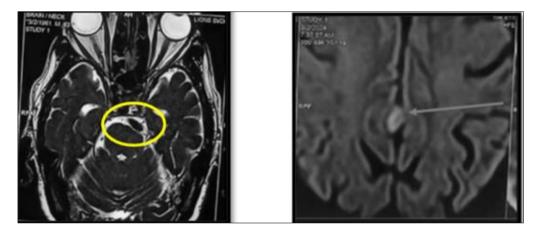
MRI shows Vertebro basilar dolichoectasia indenting over left anterior pons and left trigeminal Nerve Entry Zone region
